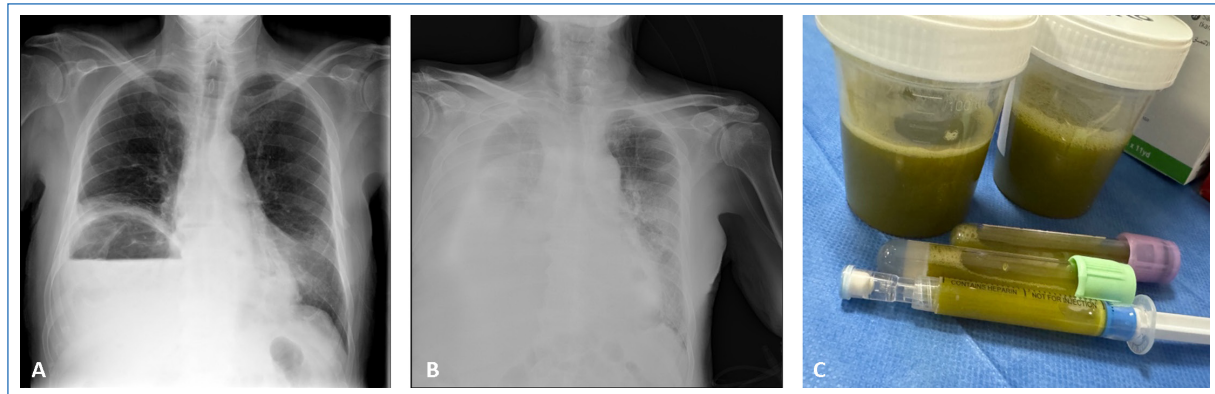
A: postero-anterior chest radiograph upon patient admission showing a right subphrenic air-fluid level (compatible with a possible subphrenic abscess) and infiltrate in the left lower lobe. B: portable antero-posterior radiograph taken 7 days after admission showing moderate right pleural effusion and bilateral infiltrates. C: right pleural fluid obtained after thoracentesis with macroscopic greenish characteristics.
